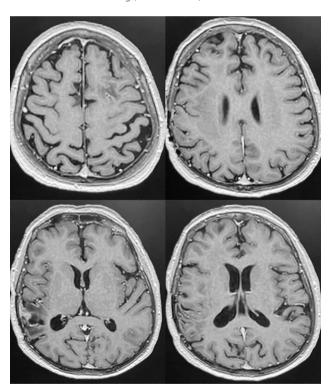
Improved imaging findings (reduction in size of lesions and edema) on follow-up axial brain MRI with IV gadolinium at 14 months
